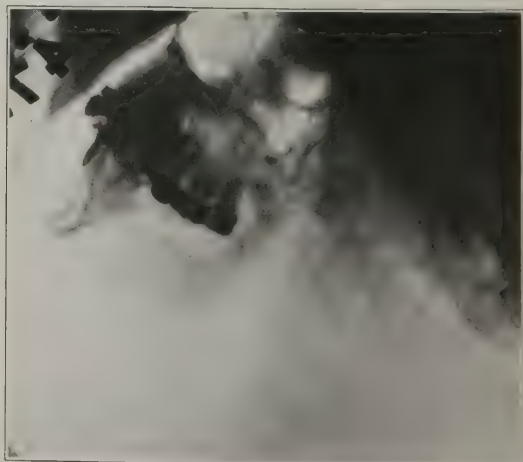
Case 5: Radiograph five months after operation, showing solidification.
